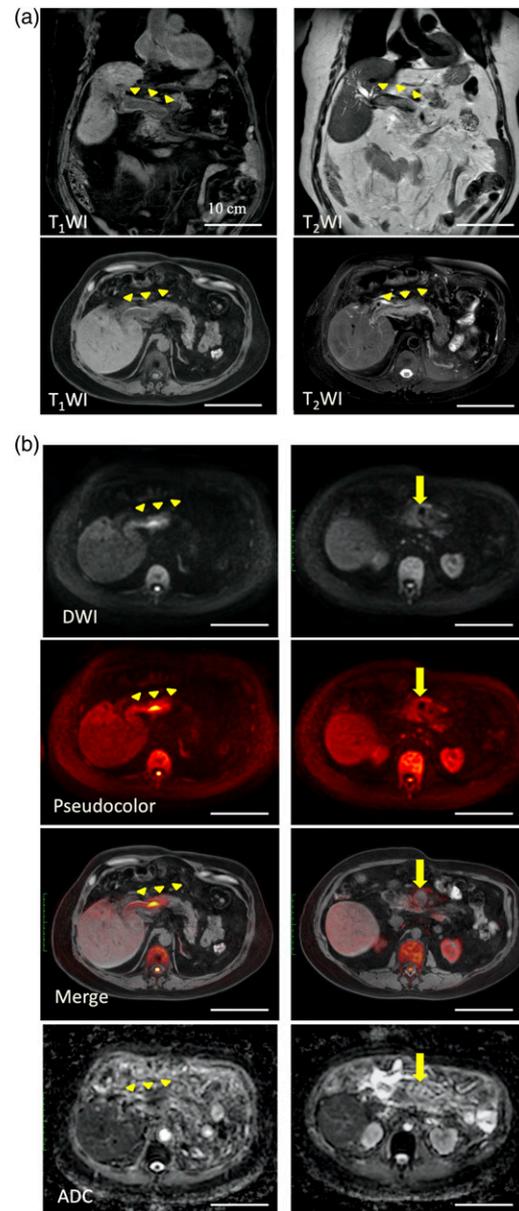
Magnetic resonance imaging of portal vein thrombosis. (a). Coronal and transverse images on T_1 WI (water image) and T_2 WI of the main portal vein thrombus. The thrombus in the main portal vein showed low to iso signal intensity with marginal high signal intensity relative to muscle on T_1 WI, and heterogeneous high signal intensity relative to muscle on T_2 WI (arrowheads). (b). Transverse images on DWI (b-value 1000 s/mm²), its pseudocolor image, a merged image of T_1 WI and DWI, and ADC of the main portal vein portion of the thrombus (left column) and superior mesenteric vein portion of the thrombus (right column). The merged image shows the main portal vein portion of the thrombus (arrow) as heterogeneous high signal intensity relative to muscle on DWI, whereas the superior mesenteric vein portion (arrowheads) is shown with low signal intensity on DWI. ADC depicts the portion vein portion with low signal intensity and superior mesenteric portion with heterogeneous high signal intensity. ADC: apparent diffusion coefficient.
